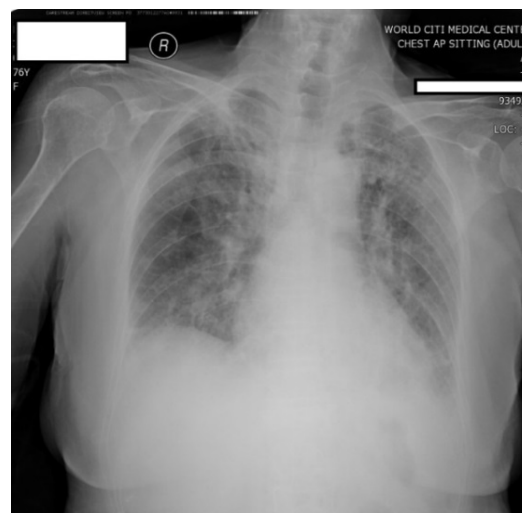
Chest X-ray at day 5 of hospitalization showing progression of bilateral hazy infiltrates.
